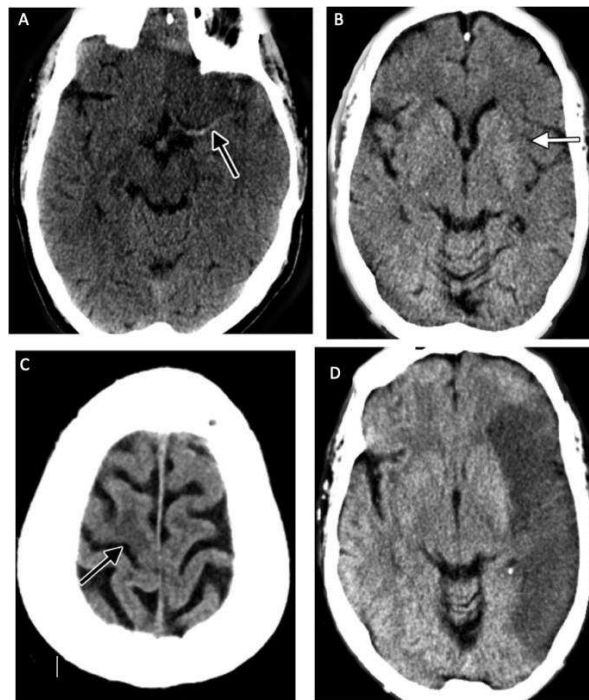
CT scan of the head without contrast, axial view, a. Hyperdense vessel sign in the left M1 MCA segment (arrow), b. shows unclear (smooth) hypodense in the insula and cortical oedema forming an insular band sign, c. loss of grey-white matter differentiation in the right frontal lobe indicates an acute infarction stroke, d. Extensive hypoattenuation of the left MCA territory and left insular edema due to vasogenic disease, indicated brain infarction/ischemic.
